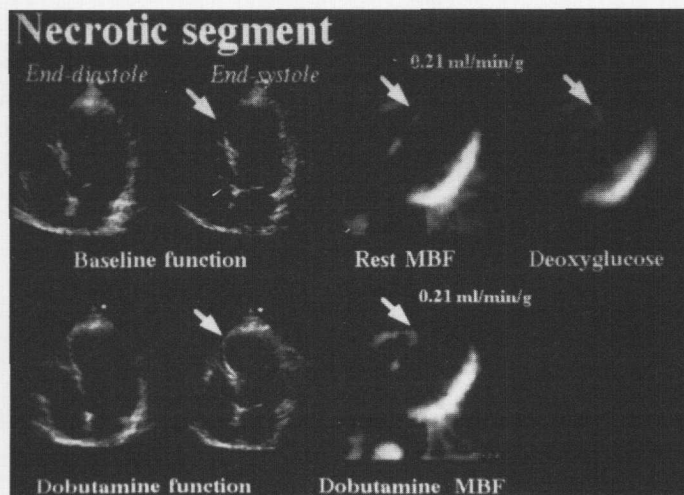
Echocardiographic and tomographic findings in myocardial necrosis. The analysis of baseline wall motion (top left) shows septal akinesia not improving during dobutamine (bottom left). PET study (right) revealed that the septal dysfunction was associated with an impaired perfusion (resting MBF) and deoxyglucose uptake raising the picture of necrosis. Dobutamine did not improve wall motion in this region and induced a limited effect on myocardial perfusion.
